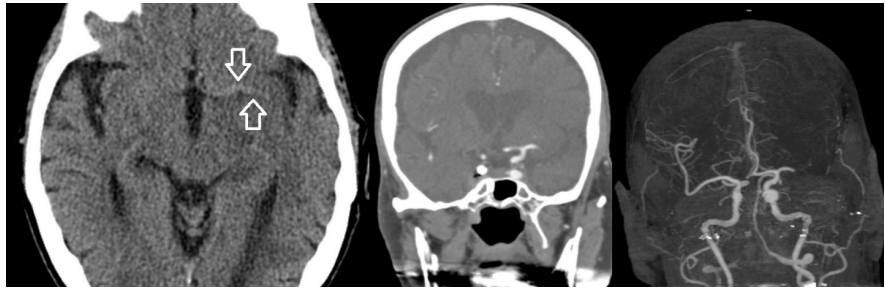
Middle cerebral artery hyperdense sign. A 90+ y/o who awoke with right hemiparesis, left gaze deviation, aphasia and NIHSS of 24. The left image reveals a hyperdense left middle cerebral artery sign (arrows); CT angiography (middle and far right images) shows a left M1 branch occlusion.
